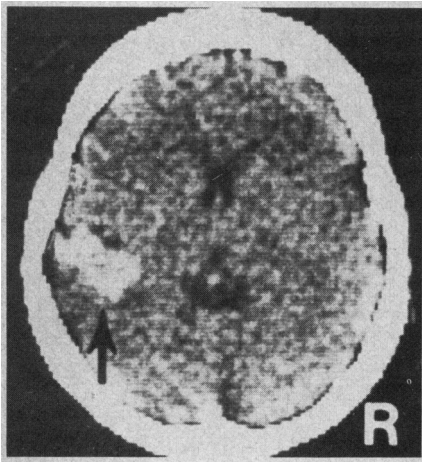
Case 7. Precontrast CT scan with calcification in left posterior temporal region (arrow).
